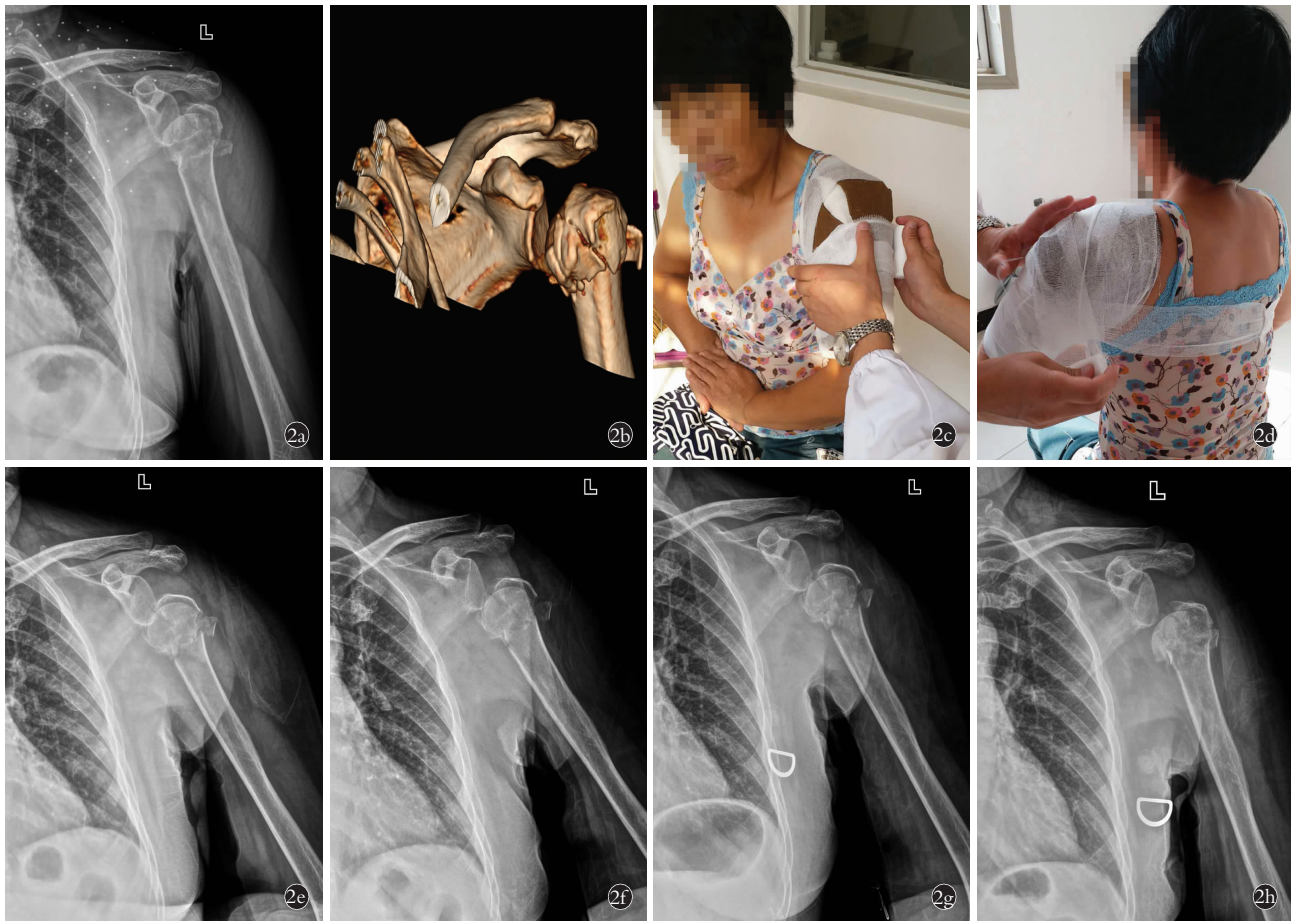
患者,女,65 岁,外伤致左肱骨近端粉碎性骨折(4 部分骨折) 2a. 治疗前左肩关节正位 X 线片示骨折断端粉碎明显,大结节分离移位 2b. 治疗前左肩关节三维重建 CT 示骨折断端粉碎呈多个碎骨块,大小结节移位 2c,2d. 患者体形偏丰满,左肩部肌肉丰厚,根据其外观形态裁剪可塑纸板,浸湿服帖后呈“8”字回旋包扎 2e. 手法复位 1 d 后左肩关节正位 X 线片示骨折断端位置较治疗前稍纠正,大小结节移位较前好转,左肩关节呈半脱位 2f. 手法复位后 1 周左肩关节正位 X 线片示骨折远端稍有嵌插,力线尚可,左肩关节仍呈半脱位 2g. 手法复位后 2 周左肩关节正位 X 线片示骨折远端间隙稍增宽,断端少量骨质吸收,位置及患肢力线尚可,左肩关节半脱位 2h. 手法复位后 3 周左肩关节正位 X 线片示骨折断端稍模糊,断端稳定,位置尚可,左肩关节半脱位
